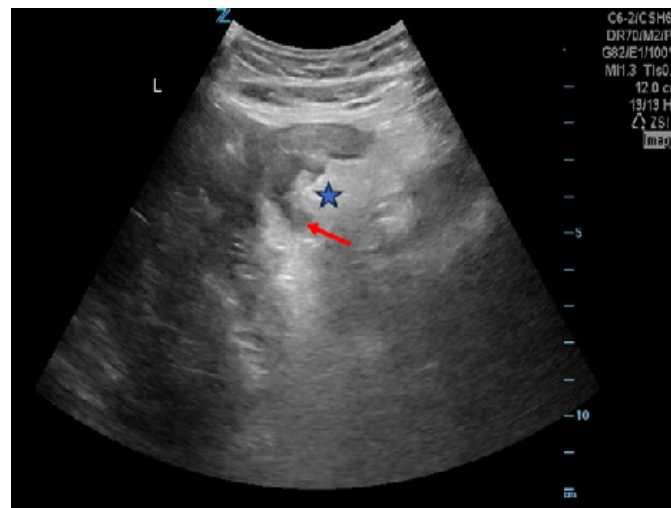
Ultrasound image obtained using a curvilinear probe demonstrates hyperechoic pericolic fat (star) surrounding a diverticulum (solid red arrow)
